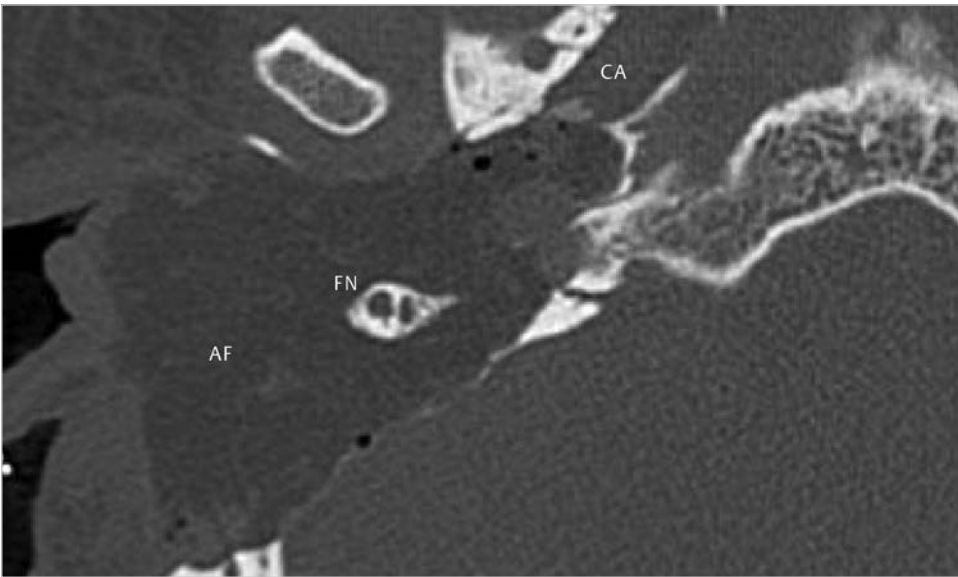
The postoperative CT shows shape of the cavity is shown. Access to the area of the carotid artery is widened by exposing the temporomandibular joint anteriorly, and the posterior fossa dura posteriorly. Preservation of the fallopian canal at the level of the mastoid segment and exposure of the carotid artery is demonstrated. AF, abdominal fat; CA, carotid artery; FN, facial nerve.
